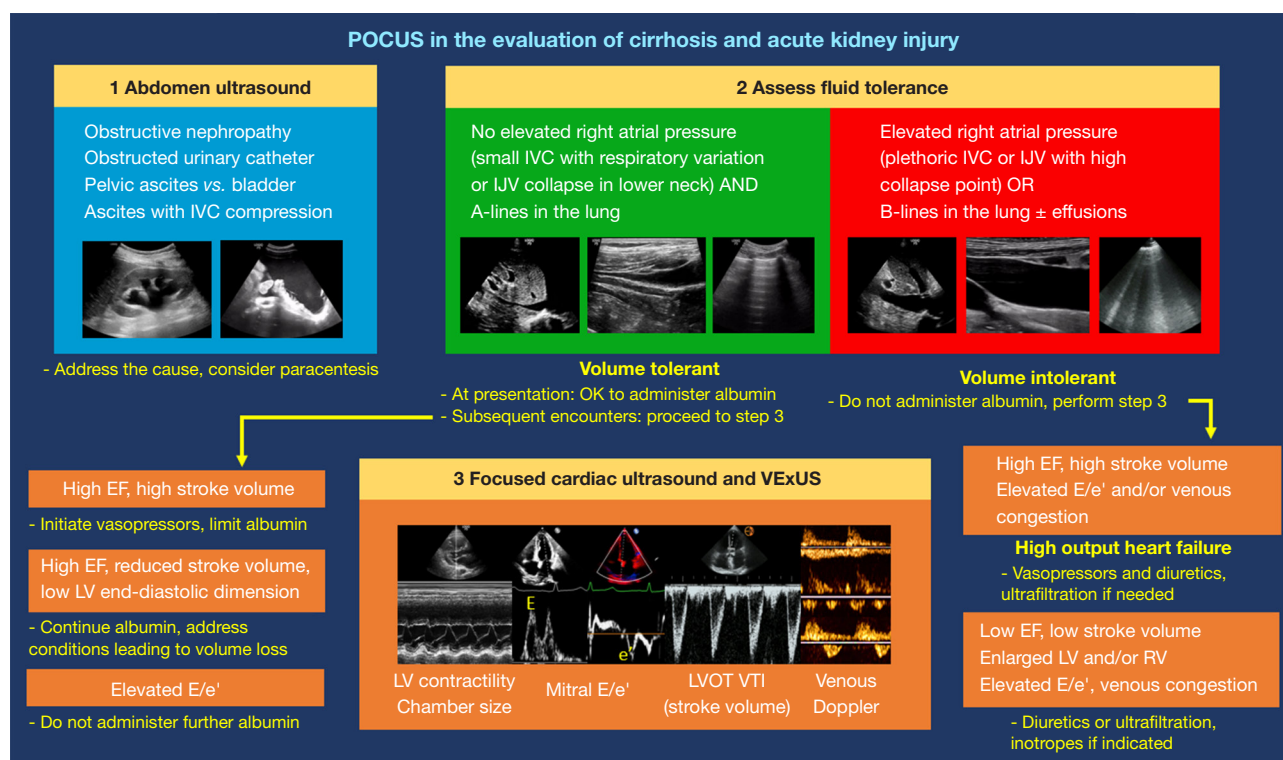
A conceptual framework for using POCUS in the evaluation of cirrhosis and acute kidney injury. A-lines, horizontal artifacts signifying normal lung ultrasound; B-lines, vertical artifacts suggestive of interstitial edema. IJV collapse point denotes narrowing/collapse of the venous column demonstrated by ultrasound, analogous to the highest point of venous pulsations on the inspection method. POCUS, point-of-care ultrasound; IVC, inferior vena cava; IJV, internal jugular vein; EF, ejection fraction; LV, left ventricle; E/e', ratio of the early transmitral diastolic wave velocity and the mitral annular tissue velocity in early diastole; VExUS, venous excess ultrasound (Doppler-assisted venous congestion assessment); LVOT VTI, left ventricular outflow tract velocity time integral; RV, right ventricle.
